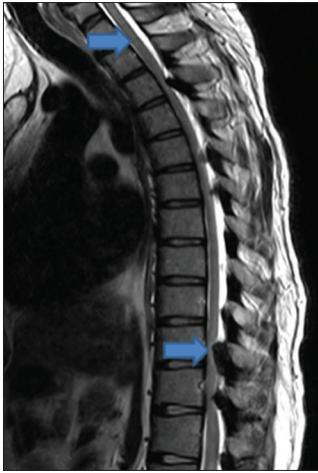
T2-weighted sagittal section showing intramedullary hyperintense signal changes at T10-T11 and T3 levels (arrows) suggesting cord edema
